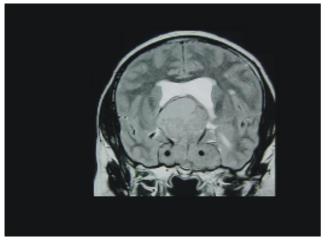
T1-weighted coronal image and B. Axial T2-weighted MR image demonstrating a Grade II giant pituitary tumor with unilateral cavernous sinus involvement. The internal carotid artery during its course in the cavernous sinus is encased by the tumor. The diameter of the artery is not compromised.
